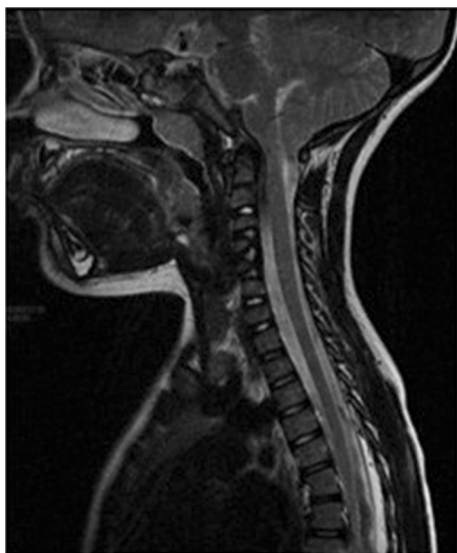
STIR sagittal MRI of twin B on presentation demonstrating stage I Chiari malformation
